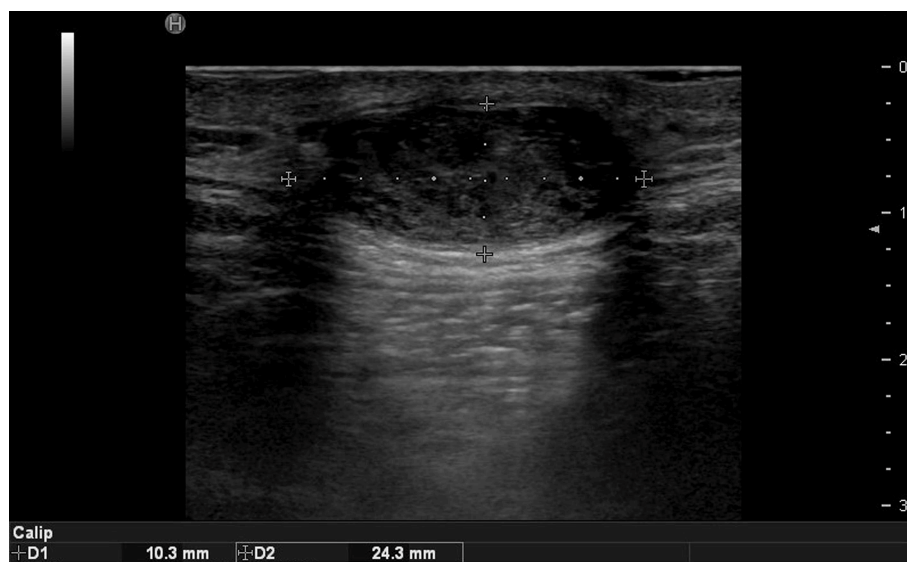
Ultrasound image of epidermal cyst.
